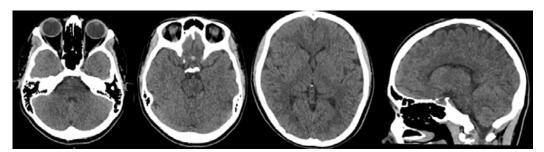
Simple CT showing adequate cortico-subcortical differentiation, centered midline, without intraparenchymal lesions.
